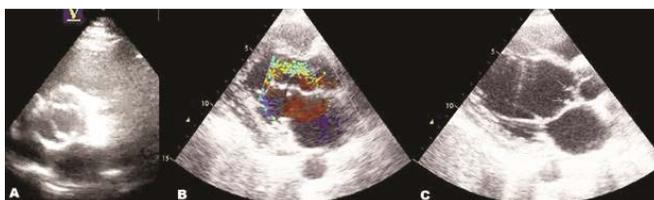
Transthoracic echocardiography on admission of the patient revealed bicuspid aortic valve (A) with severe aortic regurgitation (B) and vegetation (arrow) at left ventricular side of the aortic valve with maximum 11 mm diameter (C).
